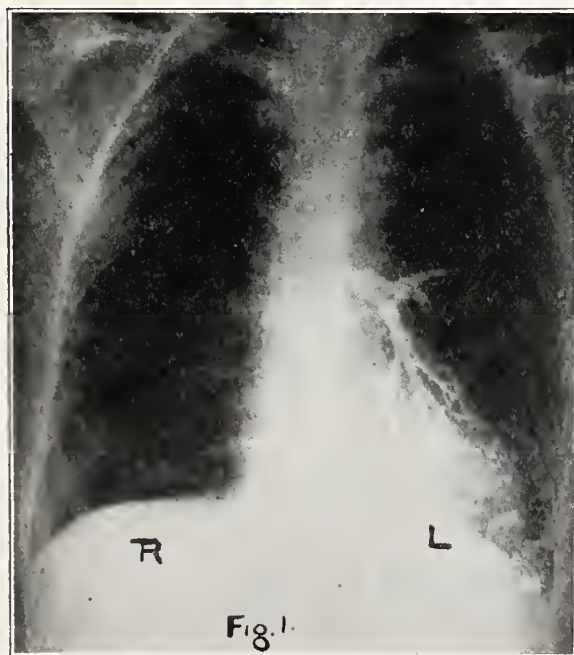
Roentgenological evidence of "internal drainage": X-ray of patient in whom iodized oil was introduced through the mouth into the left main bronchus without any type of anesthesia. Note the absence of oil in the bronchi of the right lung.
